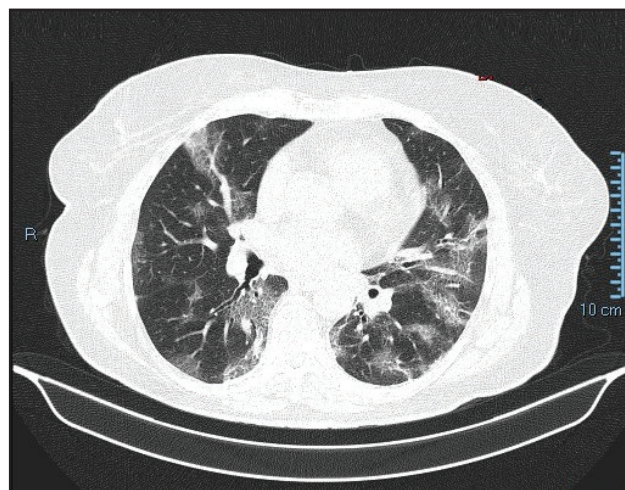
Pulmonary CT scan native in the first day of hospital admission: bilateral pulmonary condensations suggestive for lesions of SARS-CoV-2 type with severity score of 11 (6 right lung, 5 left lung) and moderate damage.
